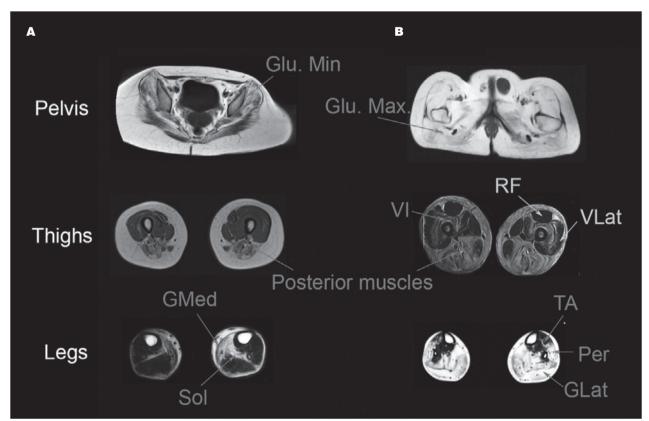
Muscle MRI in patients with mutations in the CAPN3 gene. Gluteus minimus and medius tend to be more involved than gluteus maximus (A) in most of the patients, although in advanced stages, all glutei muscles can be completely atrophic. In general, posterior muscles of the thigh are more severely involved than anterior muscles (A), but is not uncommon to find involvement of vasti muscles, especially vastus intermedius (VI). Atrophy of gastrocnemius medialis (GMed) and soleus (Sol) is frequently found (A), but in advanced cases (B) is not uncommon to find atrophy of gastrocnemius lateralis (GLat), peroneus (Per) and tibialis anterior (TA) muscles.
